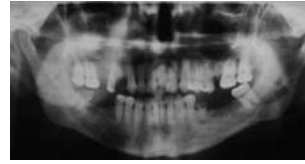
Orthopantomography showing a dental caries in the third right molar with a periapical radiolucent image.
